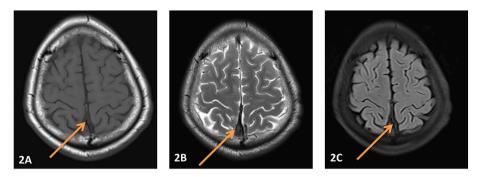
Axial magnetic resonance imaging of brain. A.) Abnormal isointense signal change in T1 weighted image due to thrombosis of superior sagittal sinus. B.) T2 hypointense signal change due to thrombosis of superior sagittal sinus. C.) FLAIR image shows isointense signal change in the superior sagittal sinus.
